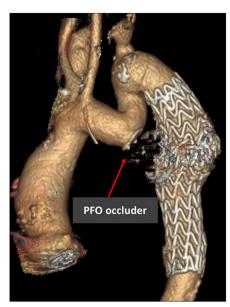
Six-month follow-up CTA shows complete occlusion of the coarctation and correction of the leak
